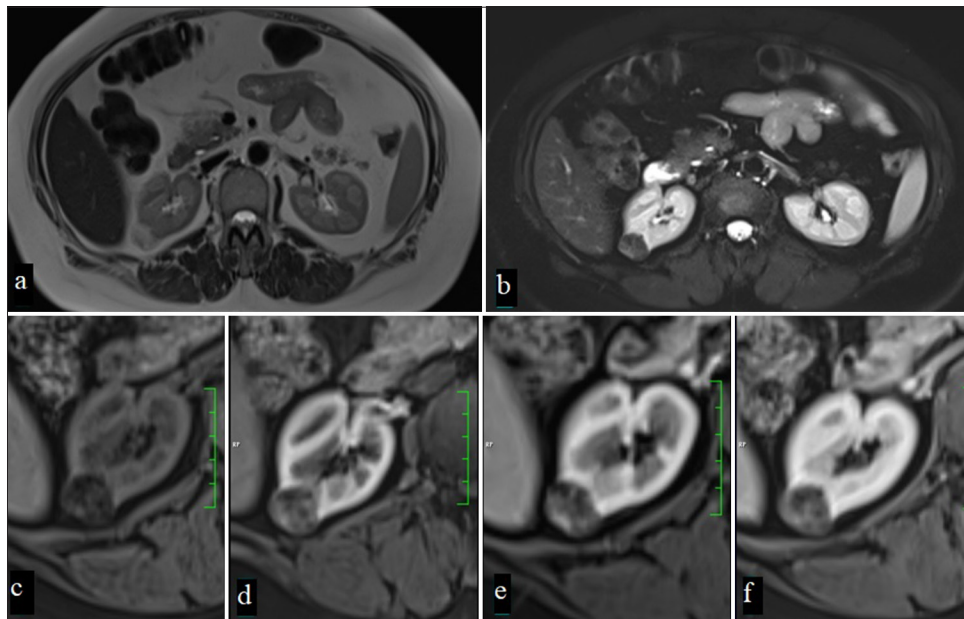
A 67-year-old man with a mass lesion in the right kidney, which appears hyperintense on T2-weighted imaging (a) and shows significant signal loss on fat-suppressed T2-weighted imaging (b) due to macroscopic fat content. In dynamic MRI, the lesion, heterogeneously hypointense compared to the renal parenchyma on precontrast fat-suppressed T1-weighted imaging (c), shows moderate contrast enhancement in the corticomedullary phase (d), nephrogenic phase (e), and (f) late phases (Angiomyolipoma).
